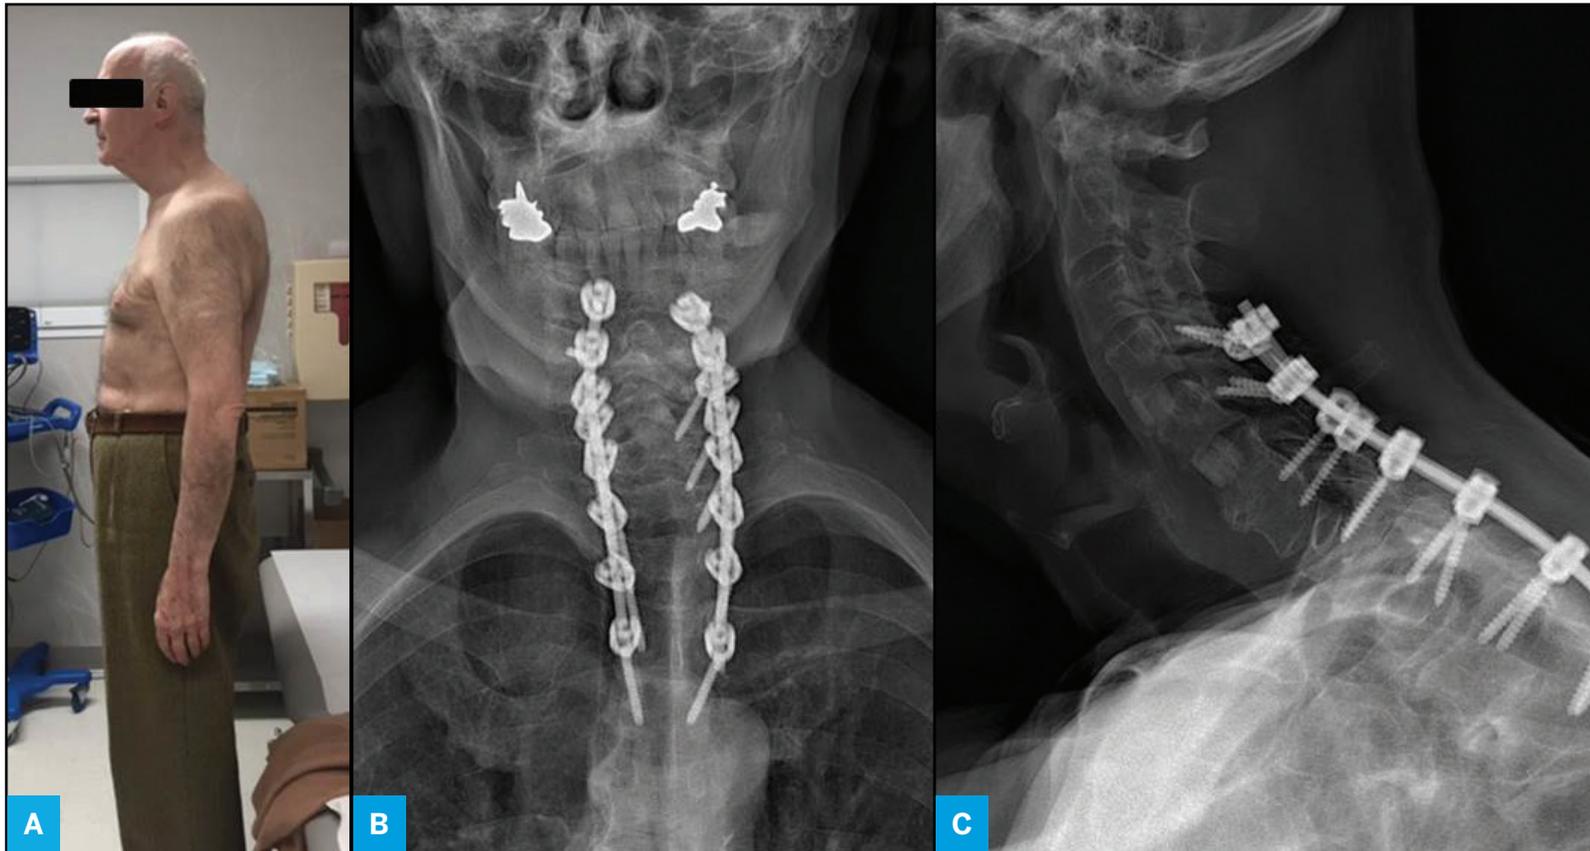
Clinical photograph (a), anterior-posterior and lateral radiographs demonstrating post-traumatic kyphotic cervical spine deformity (b and c).
